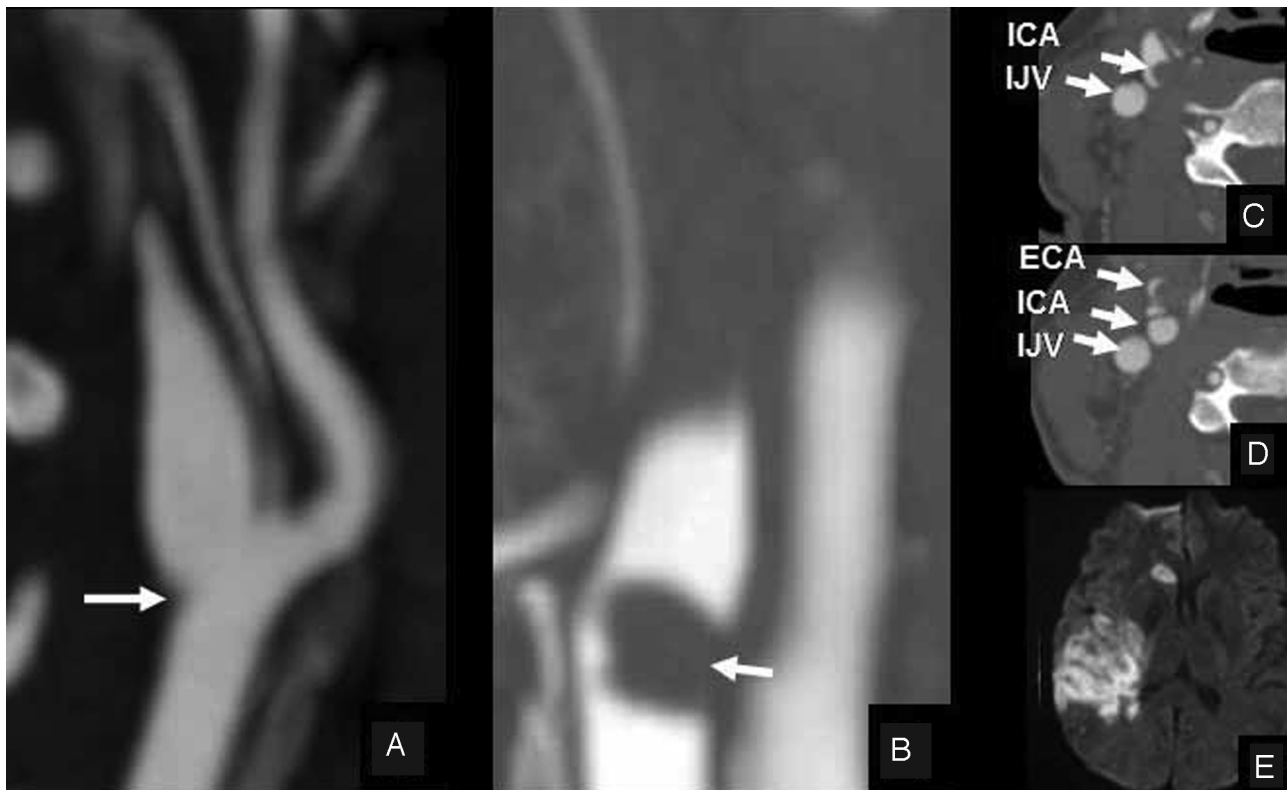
A, Admission CT angiogram shows a flame-shaped tapering occlusion of the right internal carotid artery (ICA), consistent with arterial dissection, with subtle intraluminal irregularity (arrow) suggesting thrombus at the bifurcation of the common carotid artery (CCA). C, Axial image shows the typical crescent sign of arterial dissection at the origin of the ICA and a normal internal jugular vein (IJV). B and D, Follow-up CT angiograms 1 day after intravenous tissue plasminogen activator administration show extension of the dissection into the external carotid artery (ECA) and the CCA and additional intraluminal thrombus in the CCA (arrow, B). E, Diffusion-weighted brain MR imaging shows acute infarcts in the territory of the right internal carotid artery.
